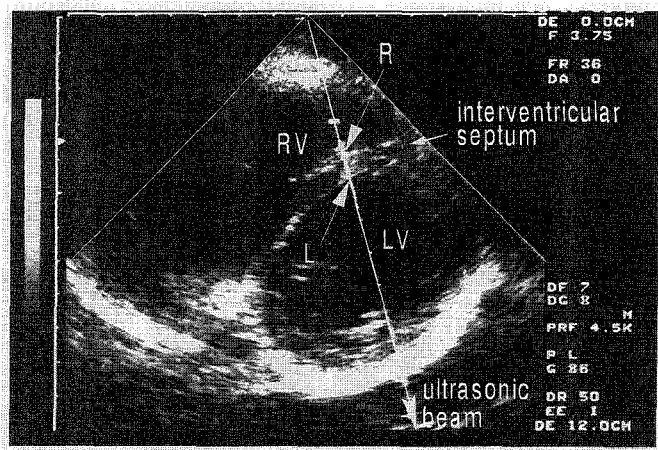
A standard B-mode short-axis image showing the cross-sectional area around the detected points preset in the interventricular (IVS) in an *in vivo* experiment for the detection of their instantaneous positions and the velocity signals of a presumably healthy 26-year-old male volunteer. Points (R) and (L) are on the RV surface and the LV surface of the IVS, respectively. The ultrasonic beam passing through the two points is almost perpendicular to the septum during the measurements.
